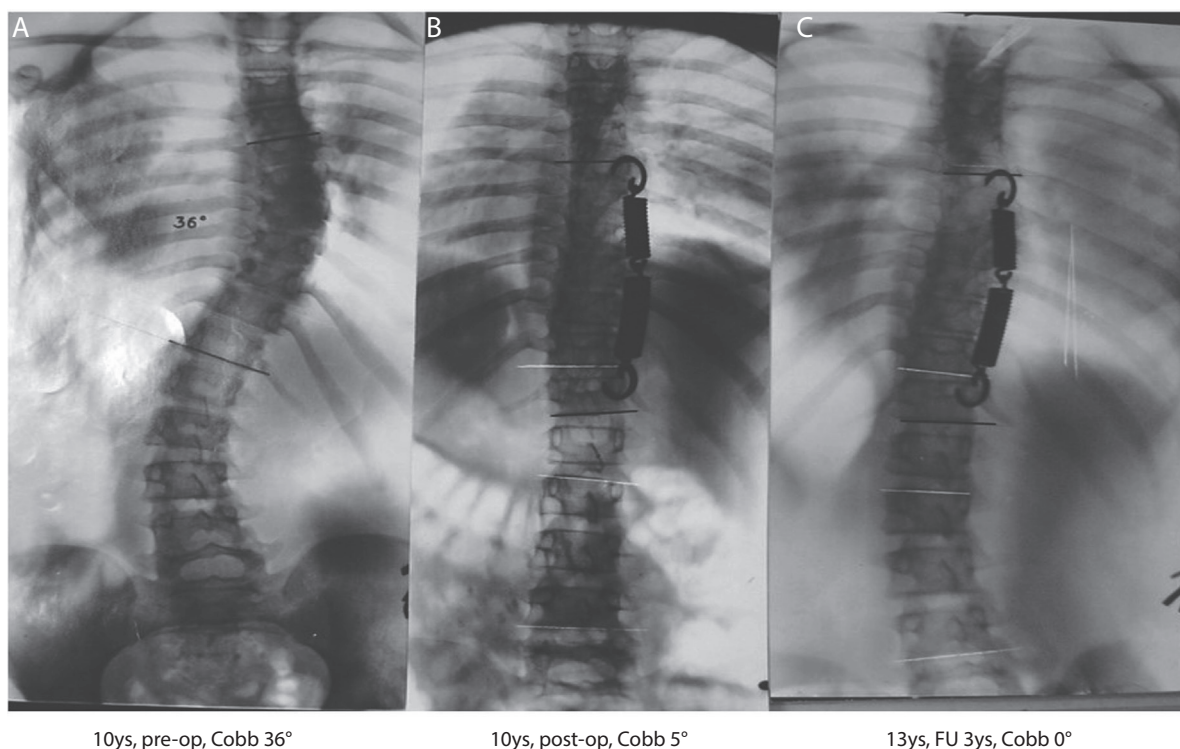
Example of a 10-year-old girl with Early Onset Idiopathic Scoliosis operated on at the Department of Orthopaedics Medical Academy in Poznań, Poland according to Gruca technique in 1961. A – Preoperative radiograph. B – Early postoperative radiograph. C – Follow-up radiograph at the age of 13 years
